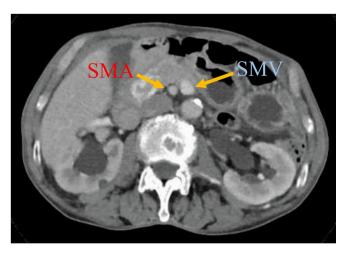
SMV rotation sign of this case. A preoperative contrast-enhanced computed tomography (CT) image of the present case showing the superior mesenteric vein (SMV) rotation sign, i.e., locations of the SMV and the SMA are interconverted.
